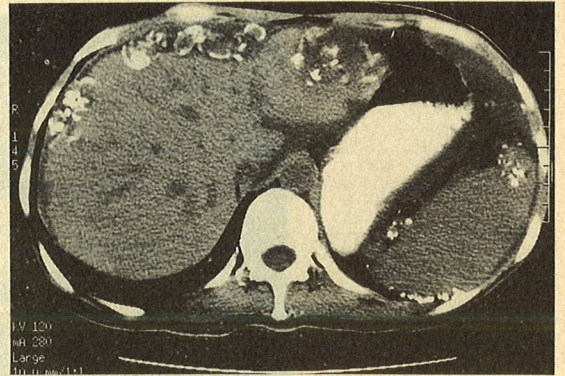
CT of the upper abdomen (no contrast).
